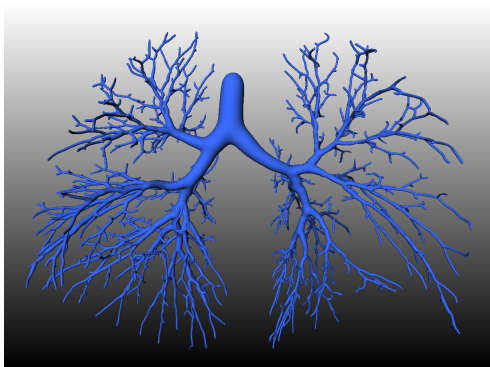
Visualization of a bronchial tree derived from a clinical CT dataset with 1504 edges.
